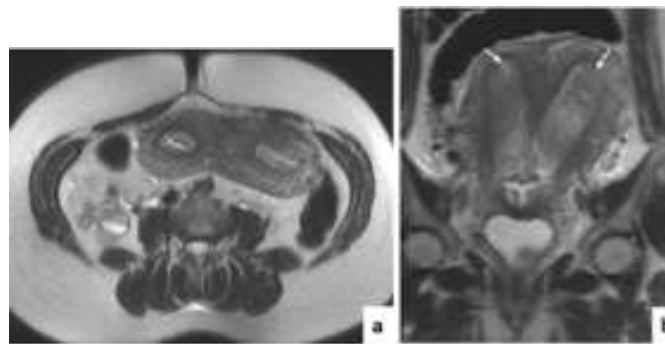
Pelvic MRI in axial (a) and coronal (b) T2 views showing 02 uterine hemimatrices (white arrows) with a common cervix and surrounded by the serosa in favor of a partial septate uterus. Radiology Department, Mother and Child Hospital, CHU Hassan II, Fez
